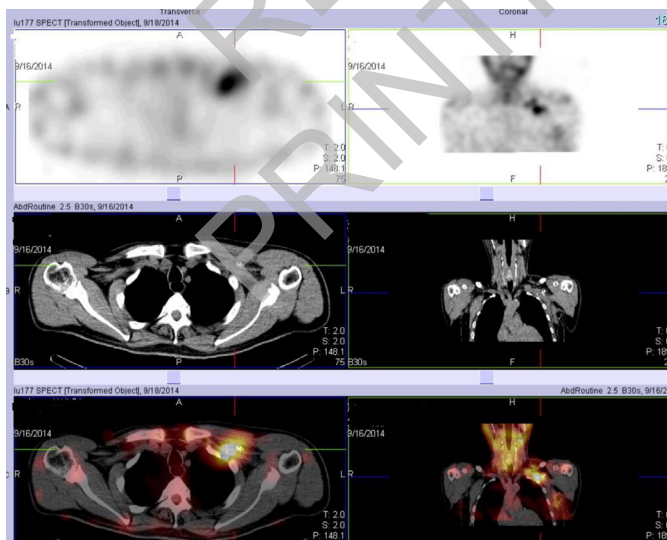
Lu177 SPECT therapy scan showing uptake in residual disease.
